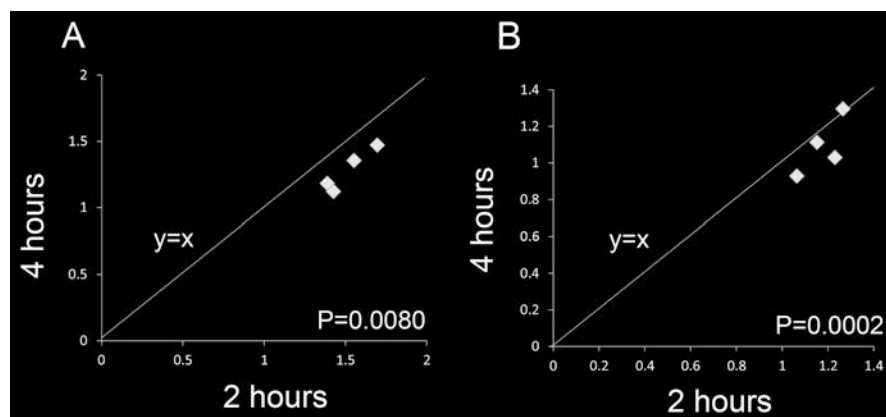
All grade II to III cases showed decrease in (a) SUV_{max}, and 3/4 cases showed decrease in (b) tumor-to-normal ratio from 2 h to 4 h
